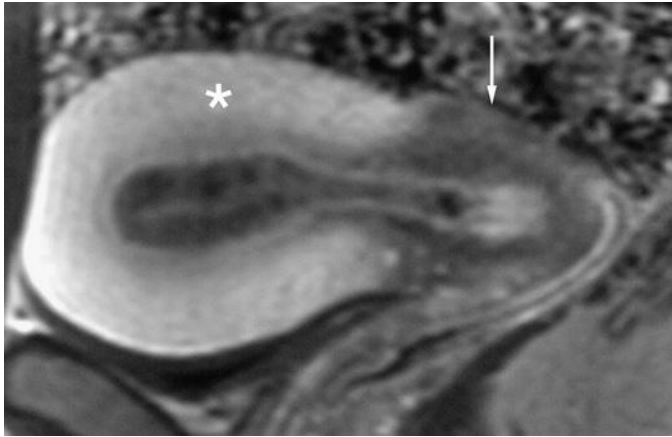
Normal uterus. Gadolinium-enhanced sagittal T1-weighted fat-suppressed image demonstrates the normal difference between enhancement of the myometrium (*asterisk*) and cervical stroma (*arrow*).
